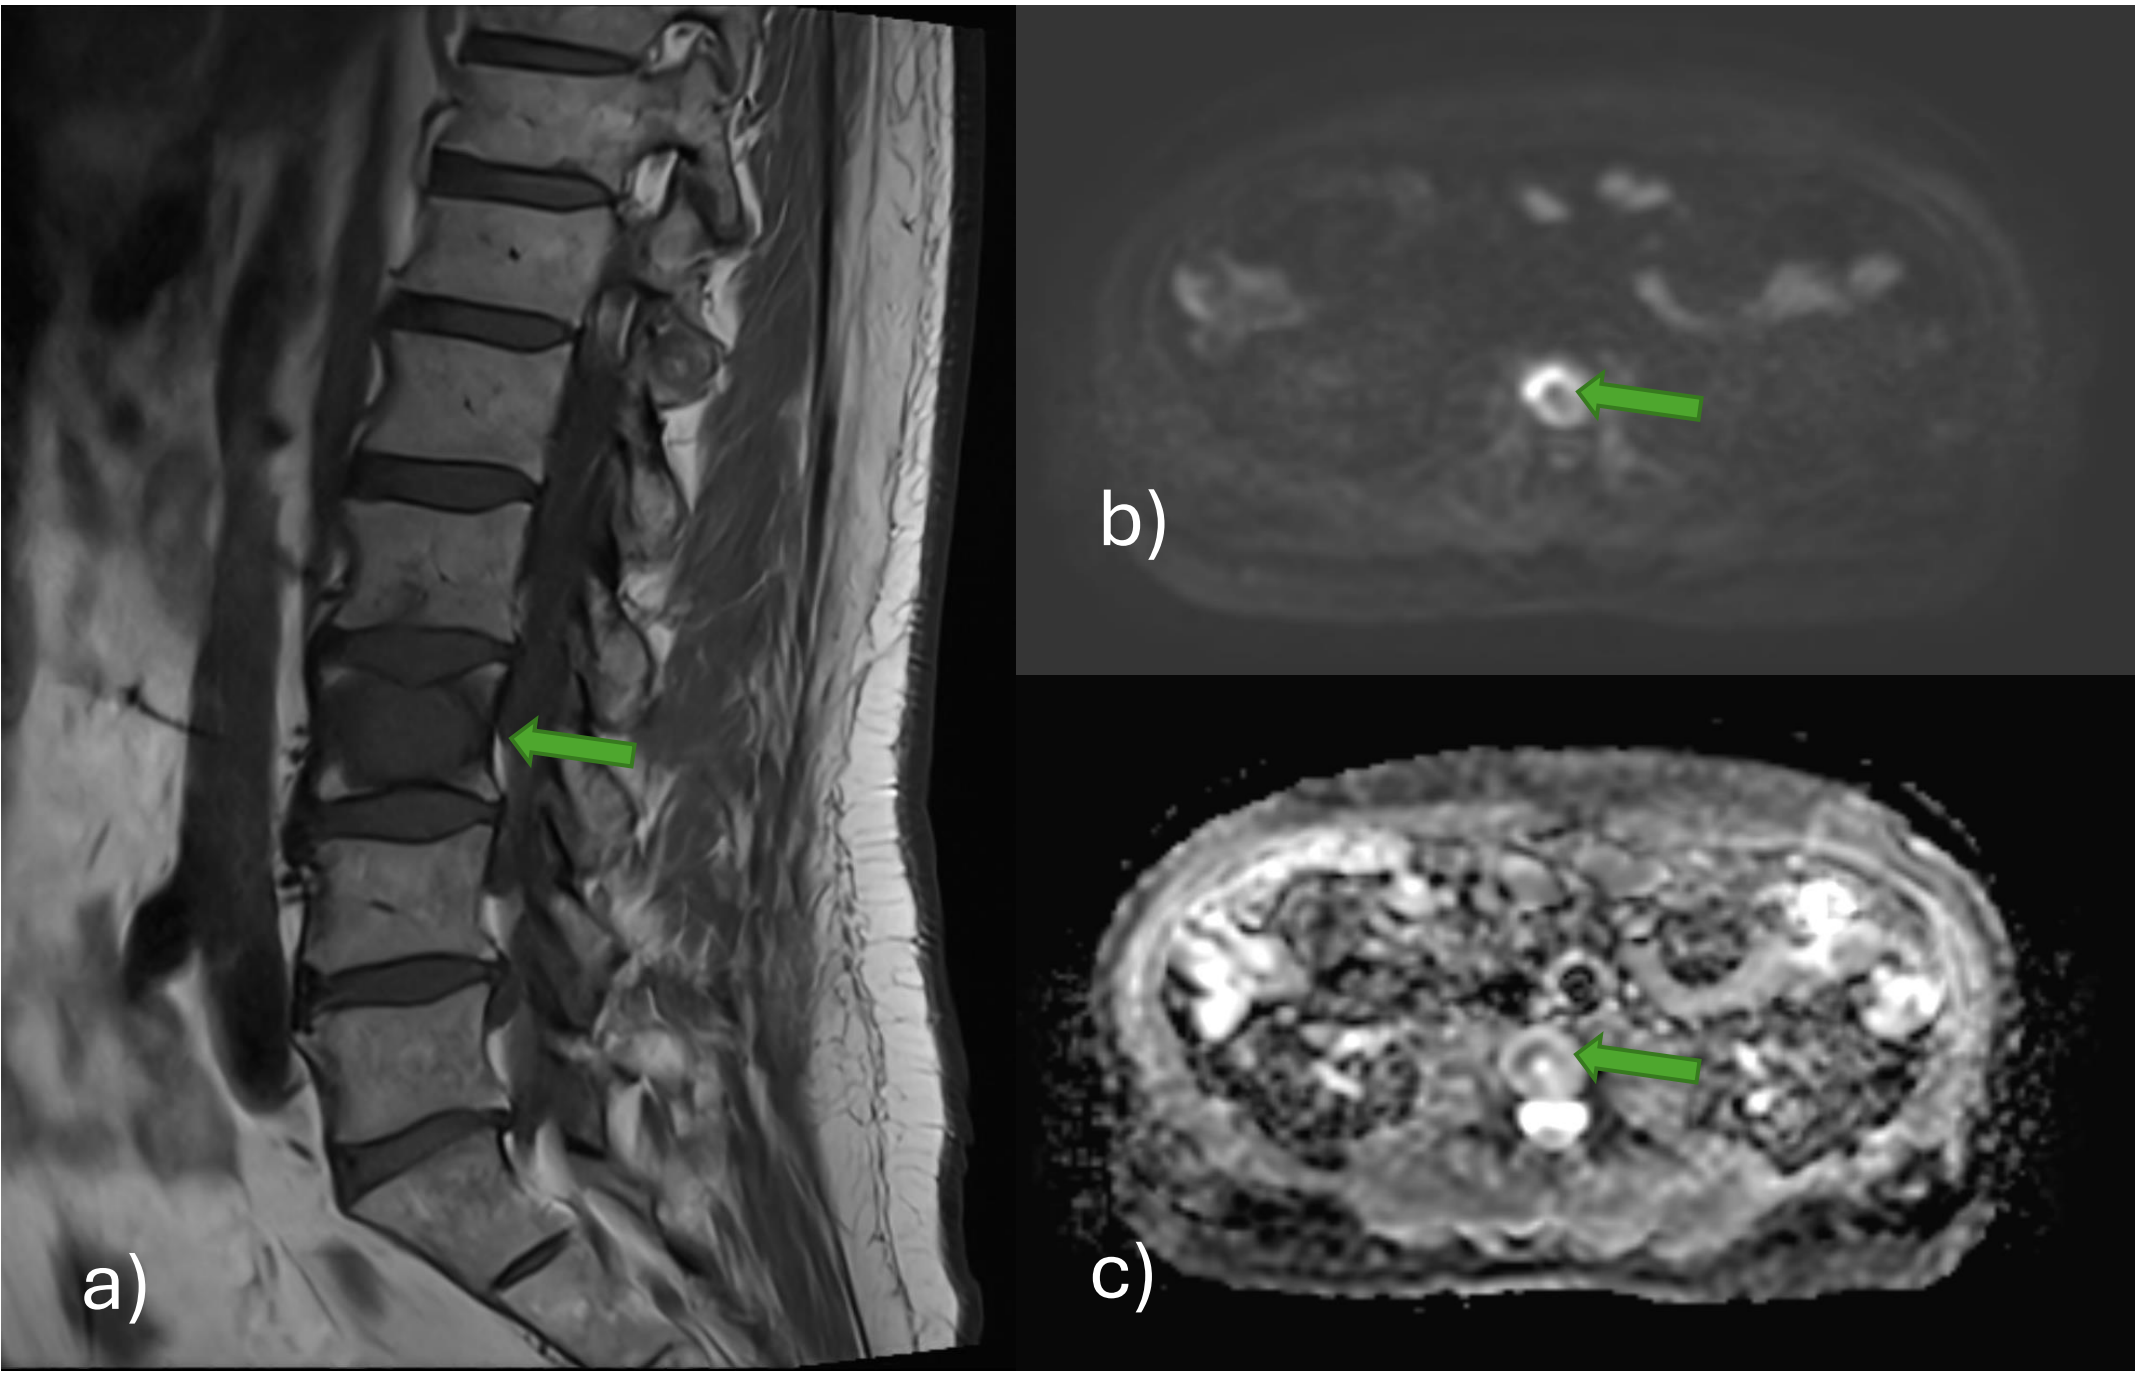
Patient no. 2. MRI of the lumbosacral spine. (a) Sagittal T1-weighted sequence: hypointense signal in the L3 vertebral body. (b) Axial diffusion-weighted imaging (DWI): hyperintense signal in the right anterior aspect of the L3 vertebral body. (c) Axial apparent diffusion coefficient (ADC) map: hypointense signal in the right anterior aspect of the L3 vertebral body. These abnormal signal characteristics are consistent with malignant infiltration of the bone marrow.
